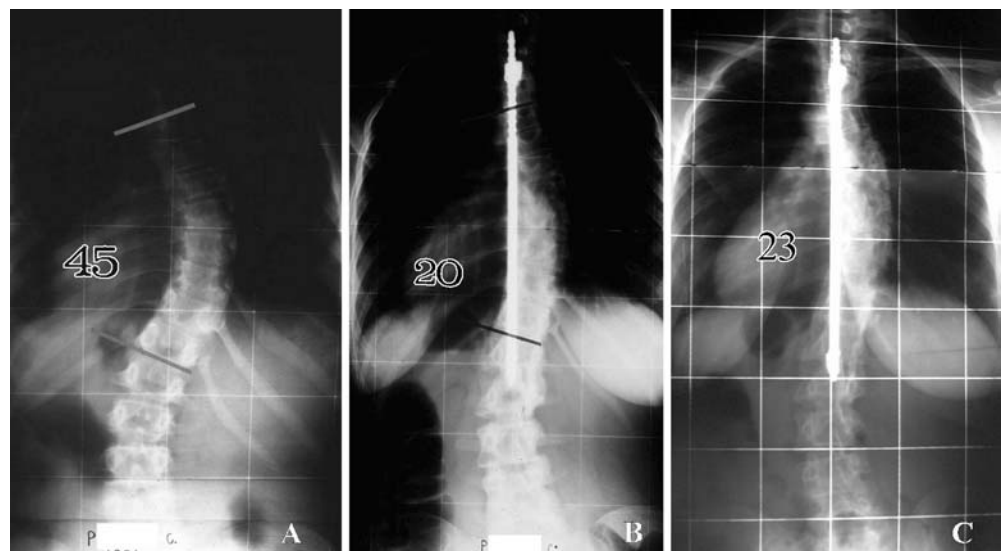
Standing sagittal view radiographs. a preoperative, b postoperative and c 21-year-follow-up
